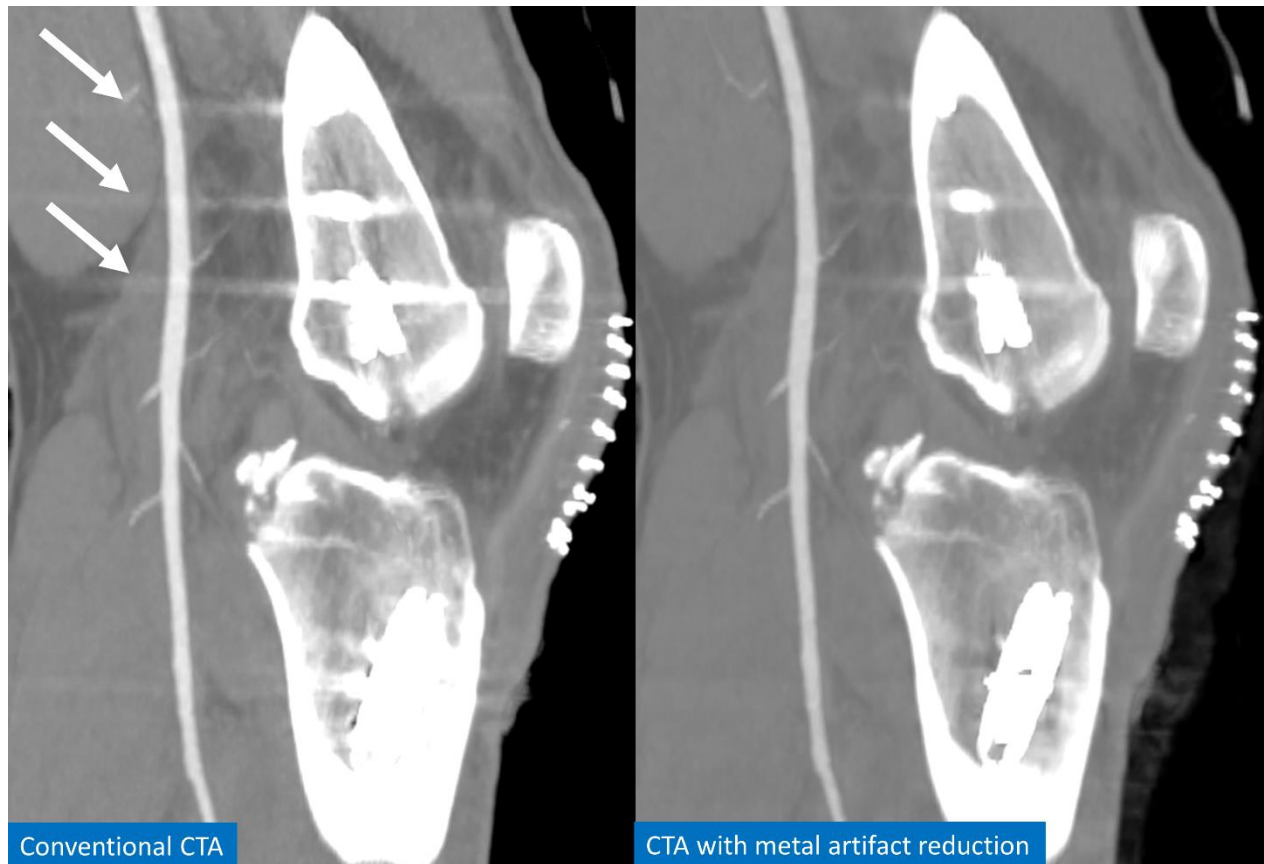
Lower extremity CTA acquired on a fast kV-switching system without and with the vendor's proprietary metal artifact reduction software (MARS). This software segments and corrects metal artifacts based on CT number thresholds [44]. Note the significant reduction of streak artifacts (white arrows) due to metallic osteosynthesis material of the femur on the MARS reconstruction.
